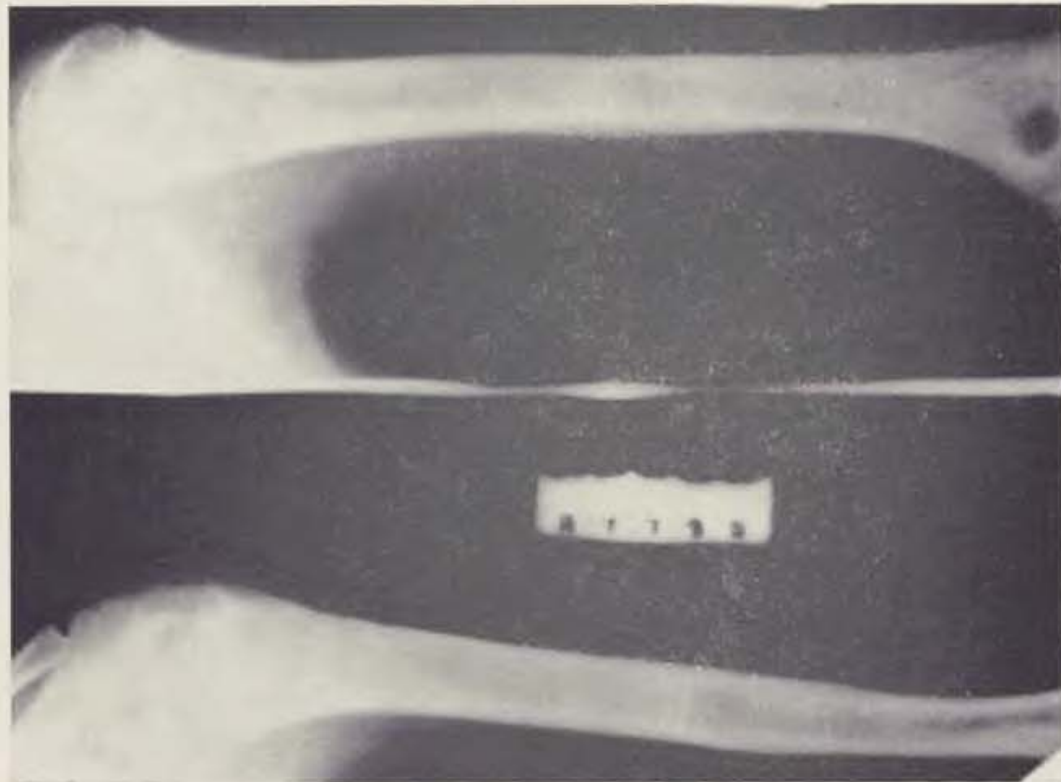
Roentgenogram 8 months after operation. Fusion of transplant with recipient bed is evident. —
